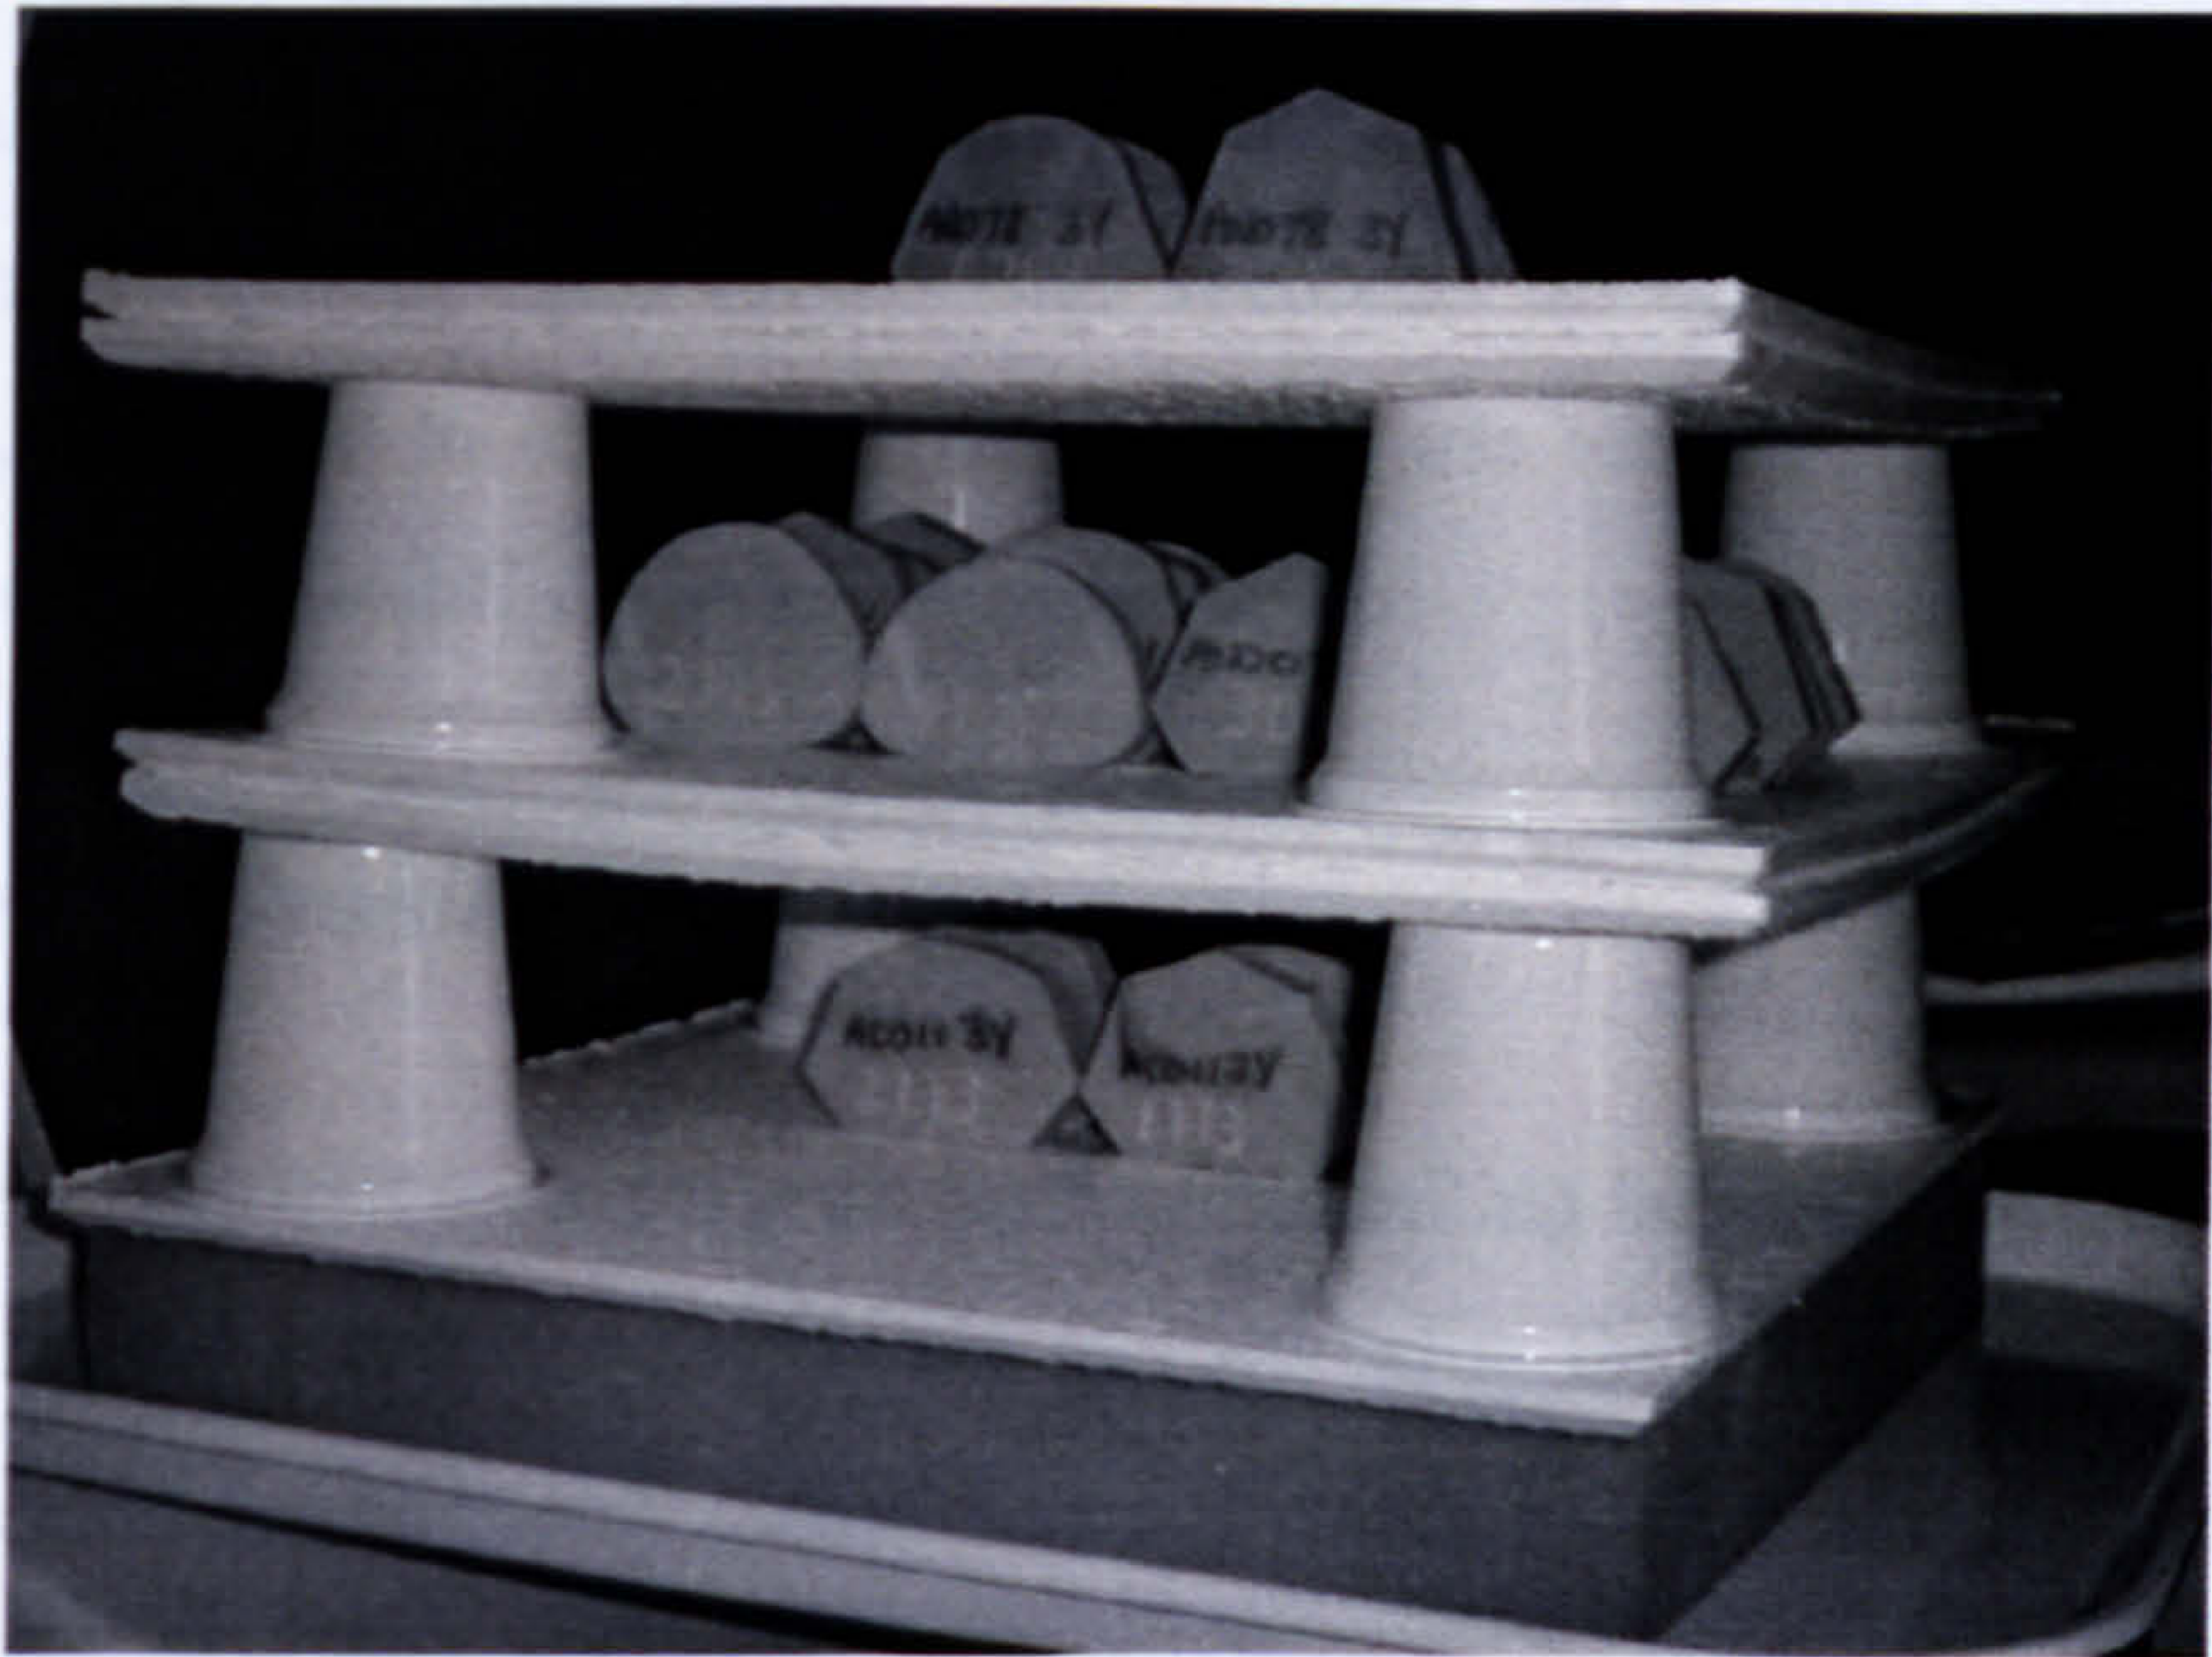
Close up view of study models in CT scanner
